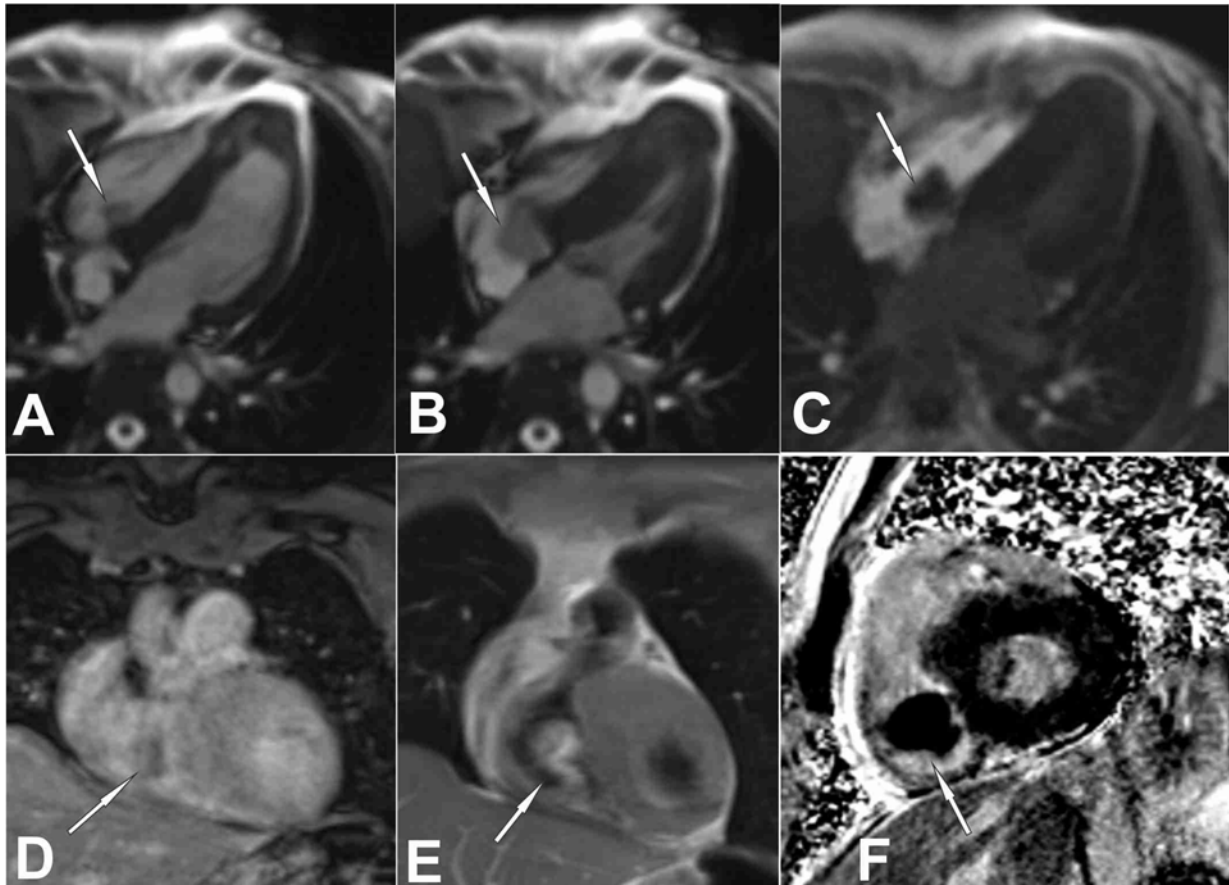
Cardiac MRI images. Cine 4 chamber heart views in diastole (A) and in systole (B) depicted the mass (arrow) and its relationship with the tricuspid valve, marked asymmetrical septal and apical hypertrophy is clearly seen. Perfusion 4-chamber heart view (C) does not show mass uptake of gadolinium (arrow) during the first pass perfusion. On the contrast-enhanced fat-saturated T1-weighted image (coronal plane) the mass (arrow) showed a signal isointense compared with myocardium (D) and hyperintense signal on coronal T2 hASTE image (E). On the late gadolinium enhancement sequence (inversion recovery) the mass (arrow) showed no contrast enhancement, suggestive of the cystic nature of the mass (F)
